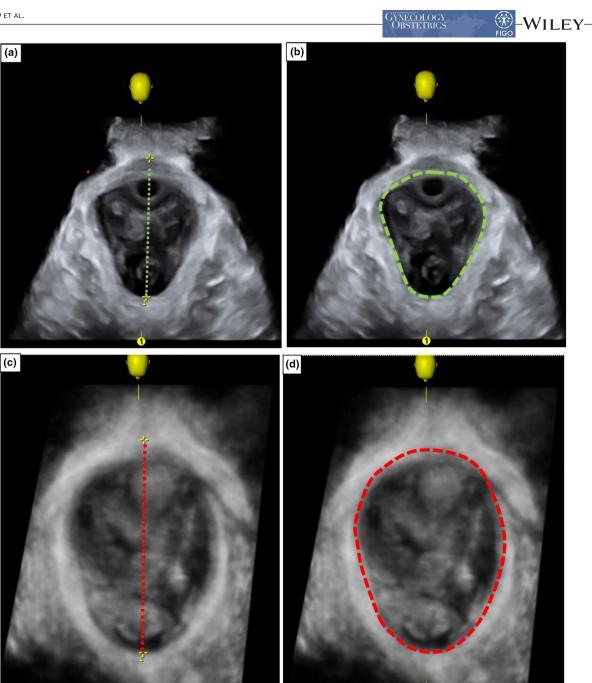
Three-dimensional/four-dimensional transperineal ultrasound showing the antero-posterior diameter and levator hiatus area at rest (a, b) and under maximum Valsalva (c, d)
